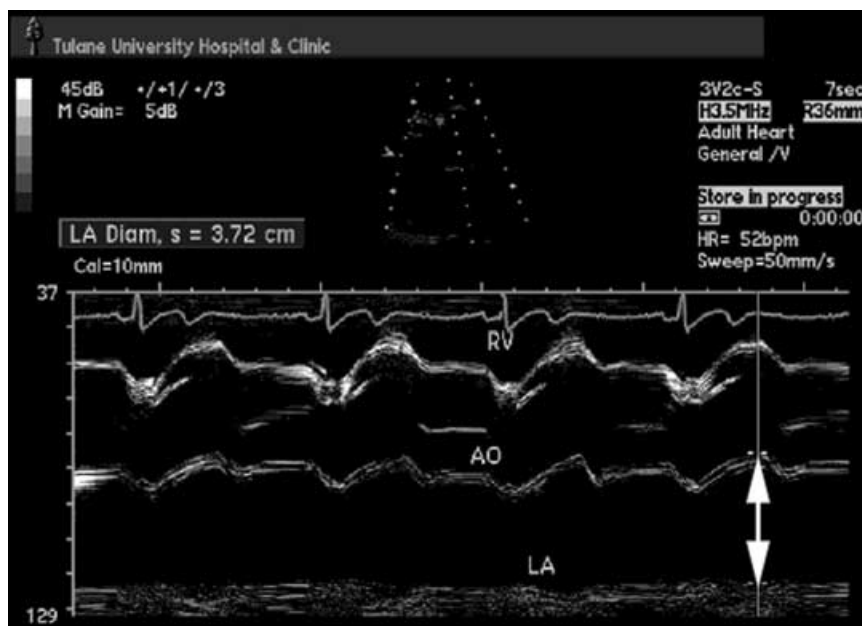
M-mode measurement of LA size from a parasternal window. According to ASE guidelines, the measurement (leading-edge to leading-edge method) is performed at end-systole, measured at the maximum dimension from the leading edge of the posterior wall of the aorta, to the dominant line of the posterior wall of the LA (arrows).
